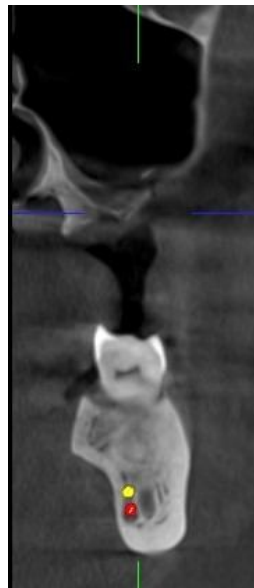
Coronal section of CBCT scan showing relation of second furcation (yellow) with the main MC (red).
